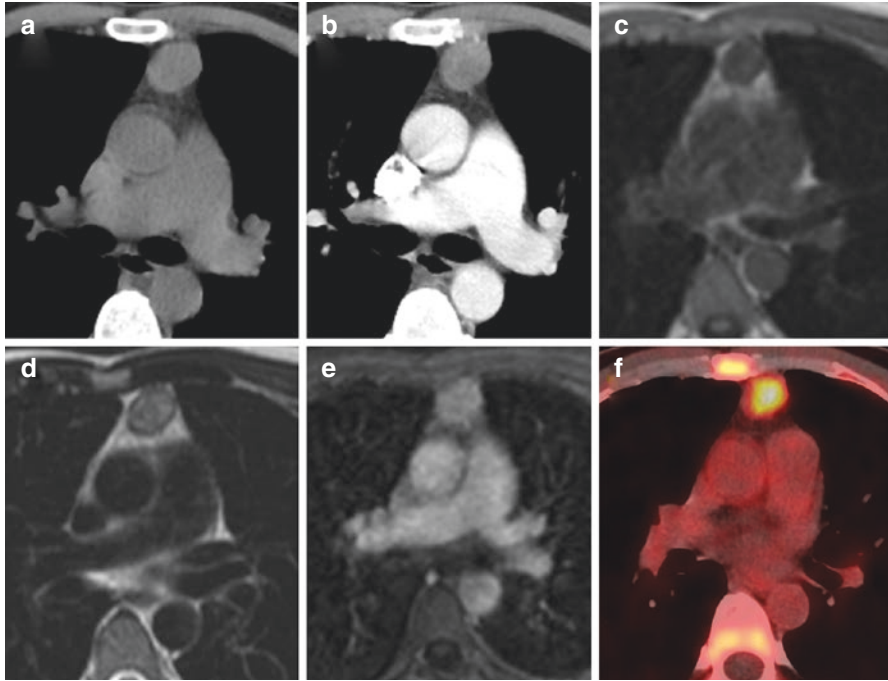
A 41-year-old man with type AB thymoma without invasion. (a) Unenhanced CT reveals a round-shaped small mass measuring 2 cm in maximal diameter, at the level of the pulmonary trunk bifurcation in the anterior mediastinum, with smooth contour, which presents soft-tissue attenuation (mean densitometric value, 37 HU), similar to that of muscles and vessels. (b) Homogeneous enhancement after contrast medium administration (intensity of enhancement, 59 HU). (c) The mass with mild low signal intensity on T1-weighted MR imaging. (d) The mass with moderate high signal intensity and smooth capsule which shows low signal intensity on T2-weighted MR imaging. (e) The mass presents homogeneous moderate enhancement on axial contrast-enhanced fat-suppressed T1-weighted MR imaging at the same level. (f) FDG-PET/CT shows moderate uptake ($SUV_{max} = 5.96$) in the anterior mediastinal tumor with non-uptake of the capsule
